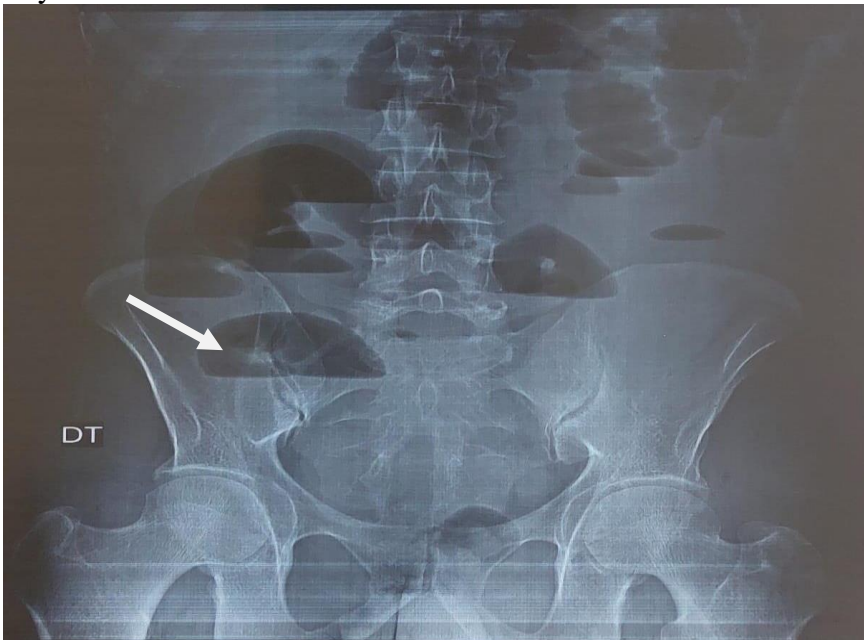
Abdominal x-ray showing dilated small bowel loops with gas-fluid levels
